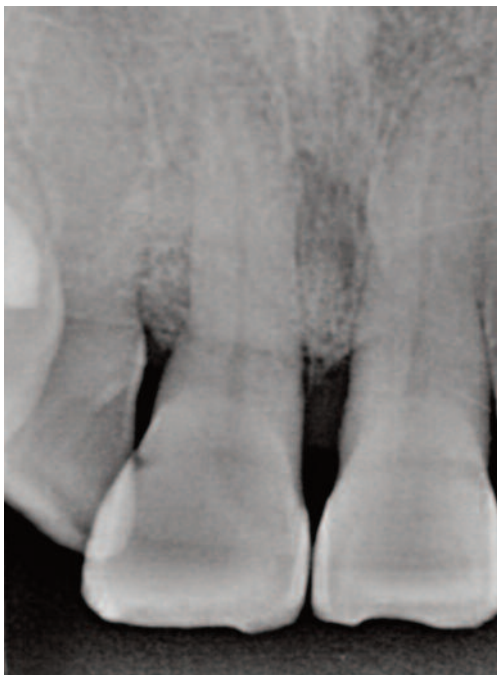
Follow-up periapical radiograph at 2 months after surgery.
